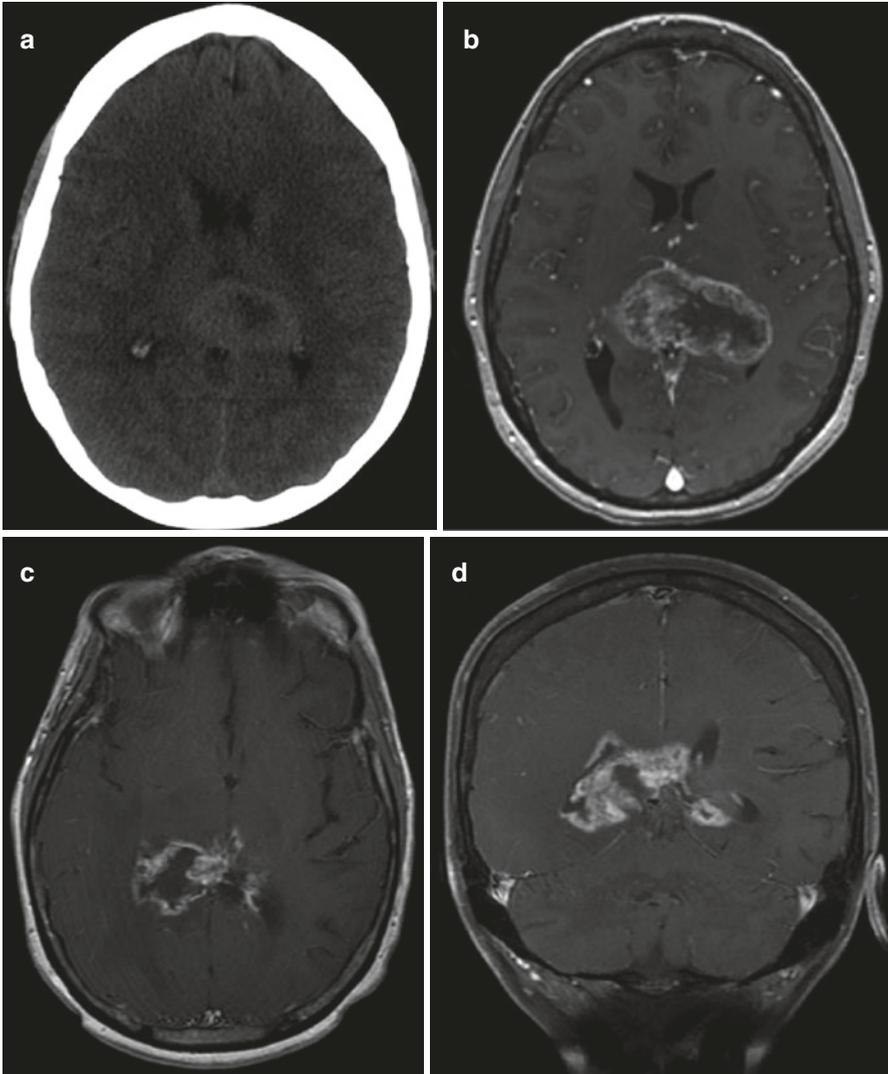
(a) and (b) are the initial CT and MRI images of the patient presenting with an intracranial mass lesion manifesting as 1 month of confusion. (c) and (d) are MRI images 8 months later showing local recurrence. (e) and (f) are MRI images from 6 months later
